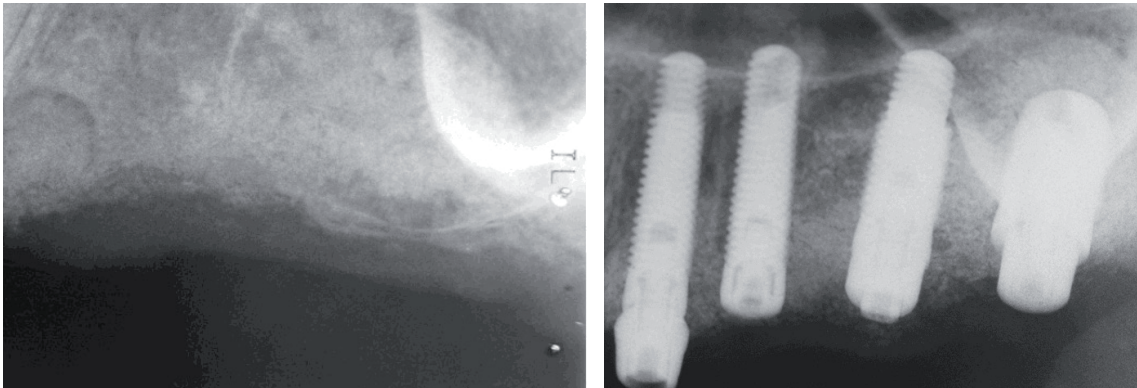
Peri-apical radiographs before and after implant placement.
